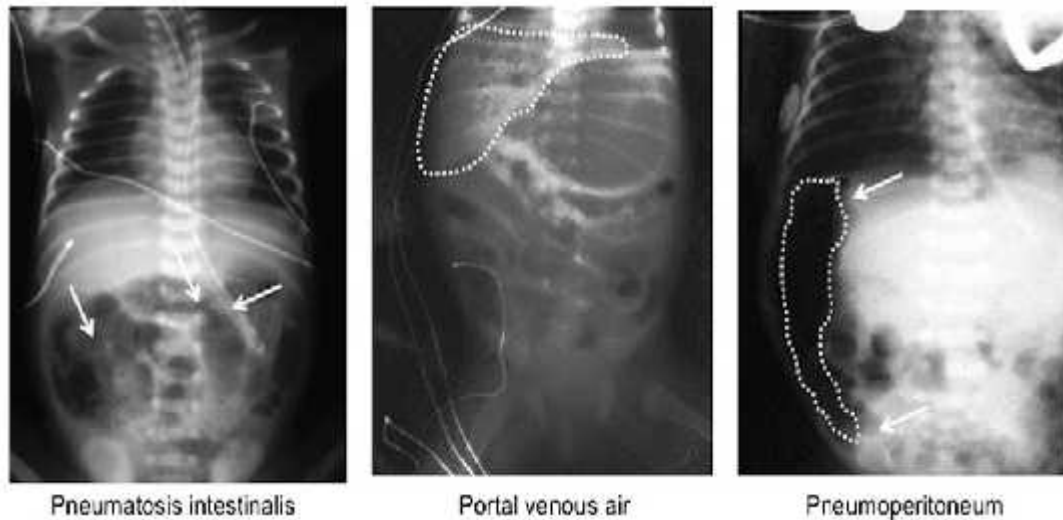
Radiographic appearance of necrotizing enterocolitis. Abdominal radiographic findings include pneumatosis intestinalis, visible as linear streaks (arrows) and "bubbly" appearance throughout the bowel; portal venous air noted throughout the liver (inside white dotted line) and dilated and stacked loops of bowel with thickened walls; and pneumoperitoneum visible as an air pocket (encircled by white dotted line and arrows) overlying the liver in the righted left lateral decubitus view.³³
